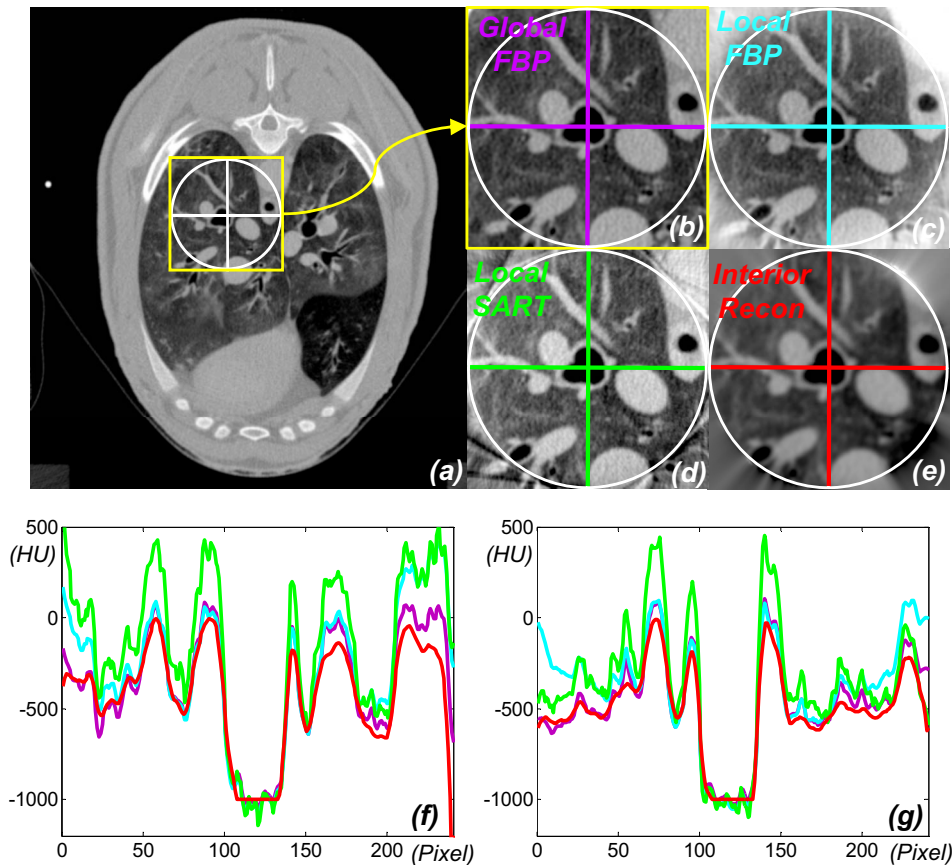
Demonstration of interior reconstruction with a lung CT scan. (a) The global FBP reconstruction containing a ROI; (b) the magnified ROI in (a); (c) the local FBP (after smooth data extrapolation and optimal constant shift); (d) the local SART (with ordered subsets and optimal constant shift); (e) the local reconstruction via interior tomography; (f) and (g) the color-coded profiles along the horizontal and vertical lines in (b)–(e), respectively. The display window is always $[-800\text{HU}, 700\text{HU}]$.
